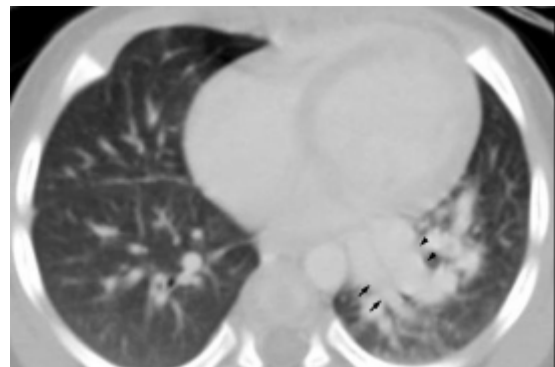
There are two large dilated vessel on chest CT( arrow: systemic pulmonary artery, arrowhead : dilated pulmonary vein)
